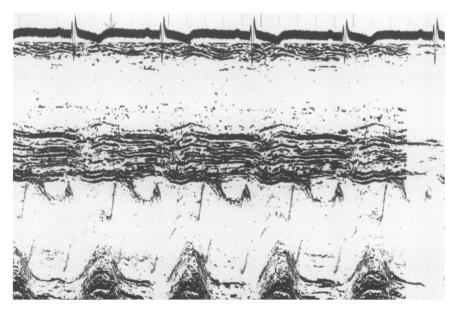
Echocardiogram of the patient's eldest son, showing asymmetric left ventricular hypertrophy and systolic anterior movement of the mitral valve.
